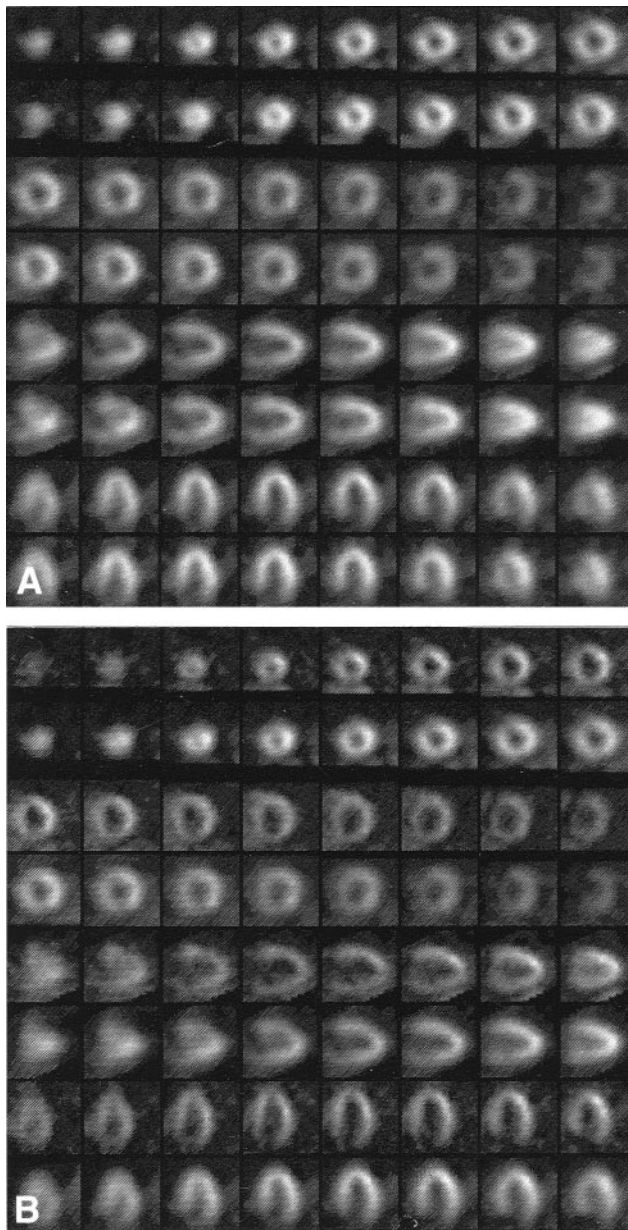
A, Rest and 4-h SPECT thallium images in a woman with severe two-vessel disease and severe LV dysfunction (EF 21%). There are severe diffuse wall motion abnormalities. The SPECT images are shown in the short-axis (apex to base, rows 1 and 3), vertical long-axis (septum to lateral wall, row 5) and horizontal long-axis projections (inferior wall to septum, row 7). The corresponding 4-h redistribution images are shown in rows 2, 4, 6 and 8 in the same orientations. There is only a mild perfusion defect involving the septum. B, Dobutamine sestamibi and rest thallium SPECT images from the same patient using the same format as in A. Here the sestamibi images are displayed in rows 1, 3, 5 and 7, and the rest thallium images in rows 2, 4, 6 and 8. There are now multiple reversible perfusion defects with transient LV dilation. This patient has a substantial amount of viable myocardium, and the LV dysfunction is secondary to myocardial stunning, hibernation and remodeling.
